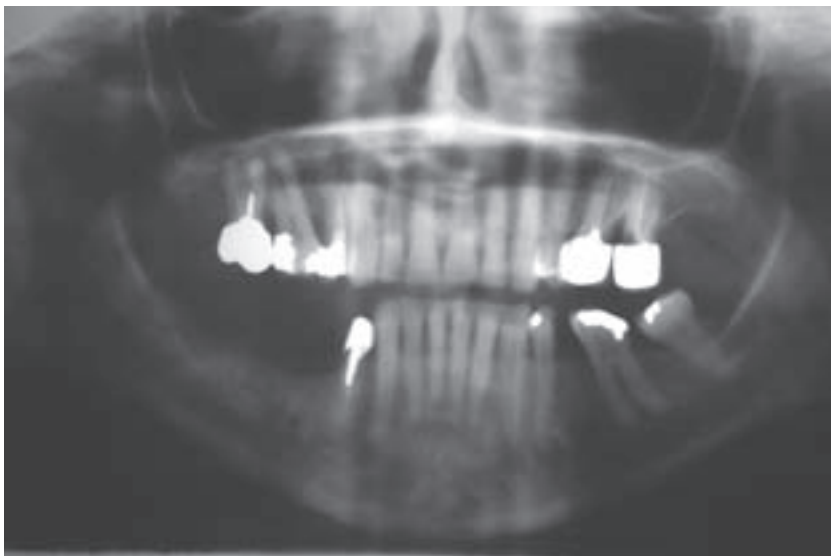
Orthopantomogram showing the edentulous area (lower right) after the abscess formation and membrane removal. Note that the residual defect after the complication occurred is more significant than the baseline defect.
